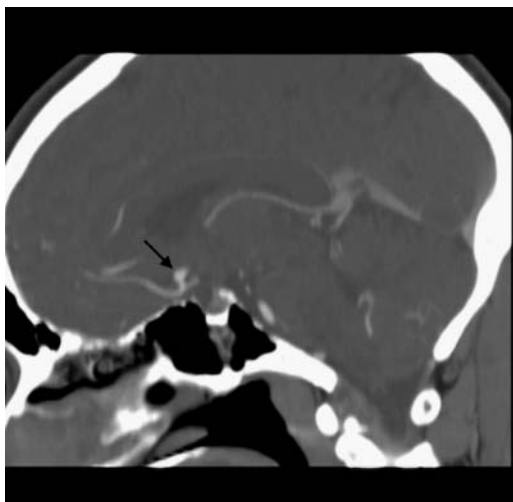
False-positive CTA (arrow).
